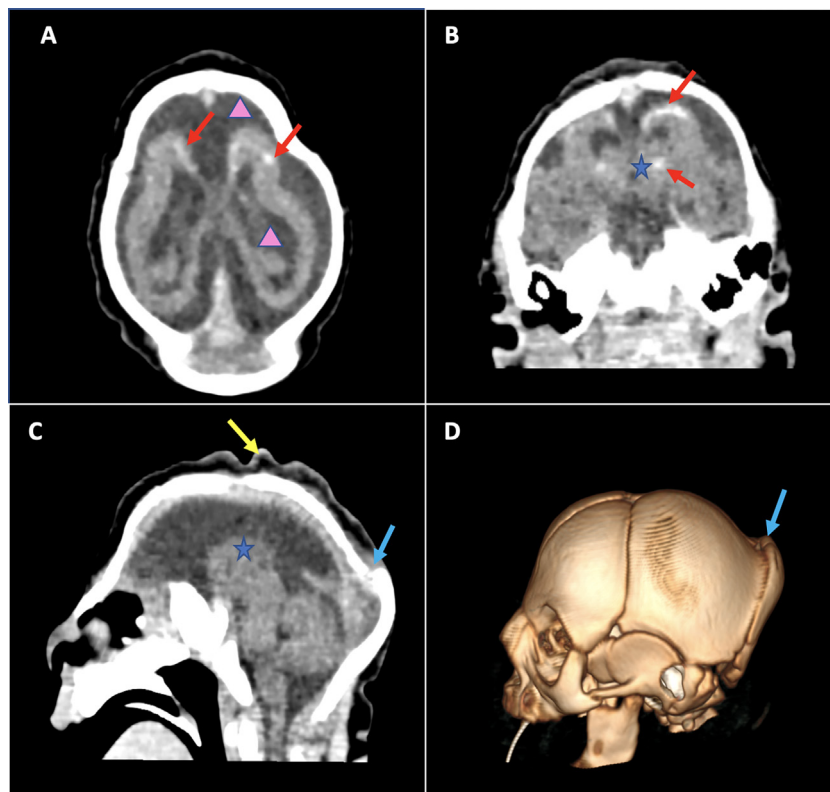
Brain- nonenhanced CT scan with axial (A), coronal (B), sagittal (C), and 3D reformatted images (D) showing a reduction in cranial volume (Microcephaly) related to Cerebral hemisphere atrophy with the absence of gyri (lissencephaly) contrasting with normal appearance of posterior cerebral fossa. Bilateral brain calcifications nodular in the basal ganglia, nodular and both linear in subcortical white matter (Red arrows, Fig. 3.A and B). Ventriculomegaly with increased fluid surrounding the brain (Pink arrowheads, Fig. 1.A), associated to the absence visualization of the corpus callosum, related to a c corpus callosum aplasia (Blue star, Fig. 3.B and C). Overriding of the cranial bones more pronounced at the parieto-occipital level (Blue arrows, Fig. 3.C and D). The whole is covered by overlying redundant scalp skin (Yellow arrow, Fig. 3.C).
